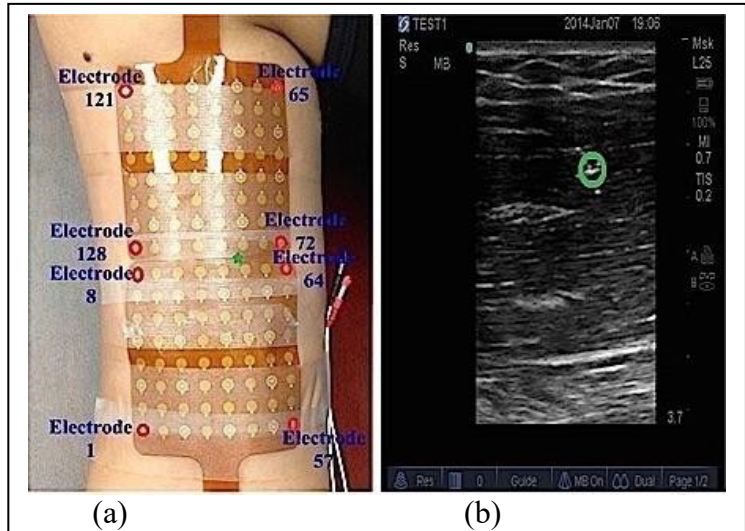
shows (a) positions of 128-channel surface EMG recording electrodes (2 flexible 8 × 8 arrays with the electrode diameter of 4.5 mm, and the center-to-center electrode distance of 8.5 mm) and wire electrode (green star) over the subject's right upper arm, and (b) location of the inserted wire electrode (green circle) in the ultrasound image of the upper arm.
